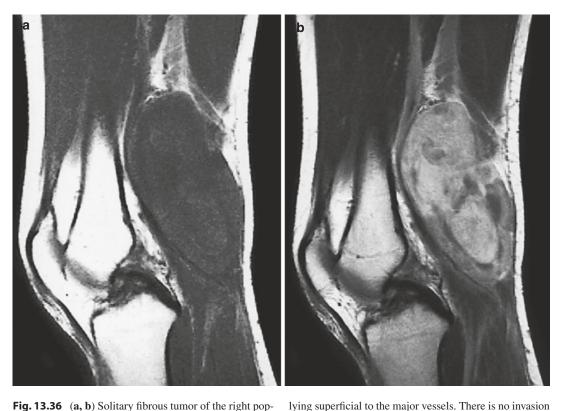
(a, b) Solitary fibrous tumor of the right popliteal fossa. (a) Sagittal T1-weighted MR image. (b) Sagittal T1-weighted MR image after gadolinium contrast injection. An oval, largely homogeneous lesion is seen
